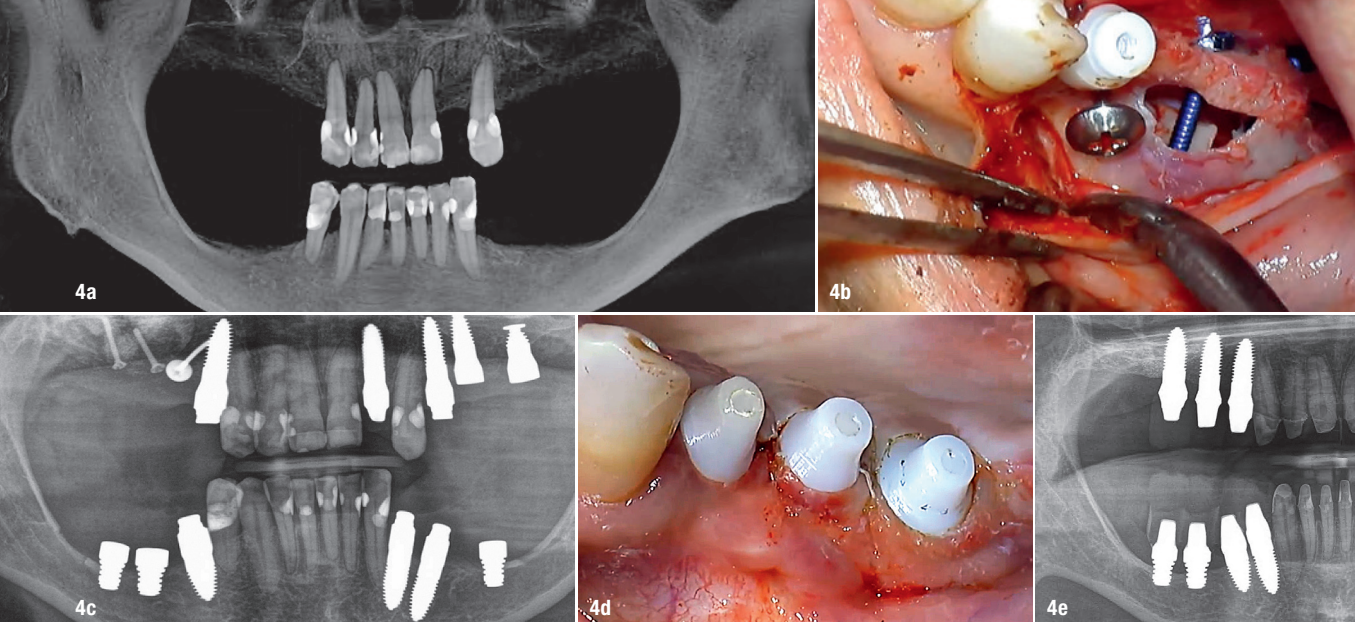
Pre-op CBCT scan (a), intra-op image of regions #17 and 16 after insertion of the osteosynthesis screws (b), post-op panoramic radiograph (c), situation after healing of the bone and implant placement in regions #17 and 16 (d), panoramic radiograph recorded after implant placement in regions #17 and 16 and restoration with long-term temporary restorations (e).
